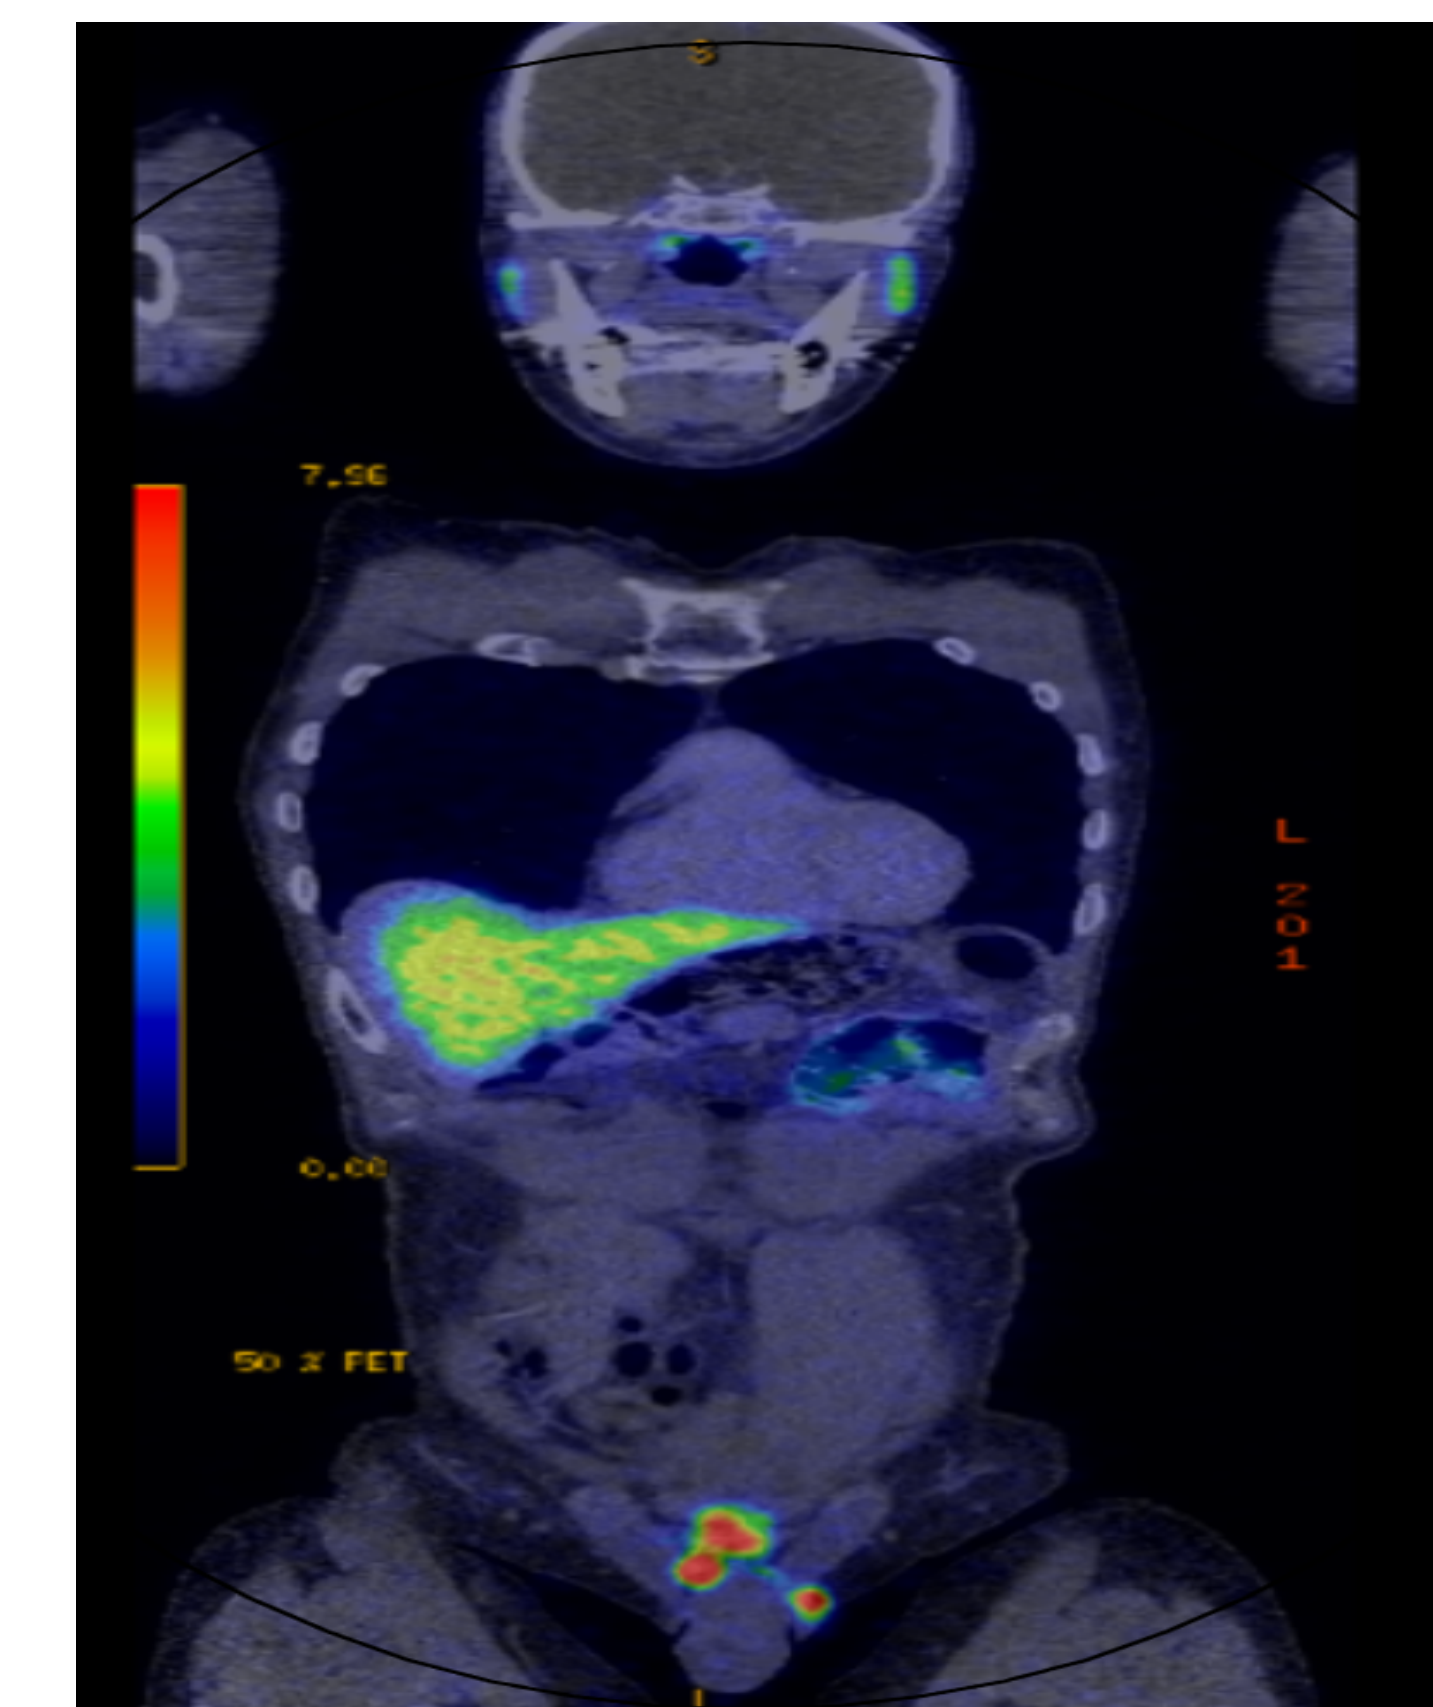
68yo male with rising PSA on a background of radical prostatectomy in 2010 who was referred for re-staging. 68-Ga PSMA PET/CT demonstrated five foci of avid PSMA positivity in the base of the penis/scrotum in keeping with residual neoplastic disease.
